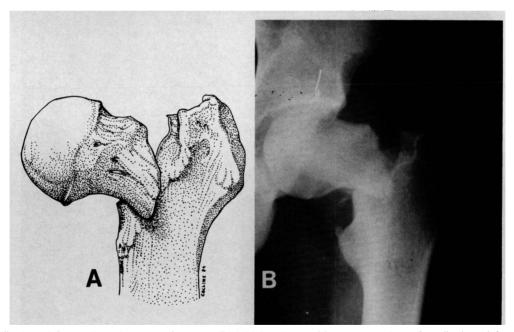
A, displaced femoral neck stress fracture. B, initial radiographic presentation of a displaced femoral neck stress fracture.
